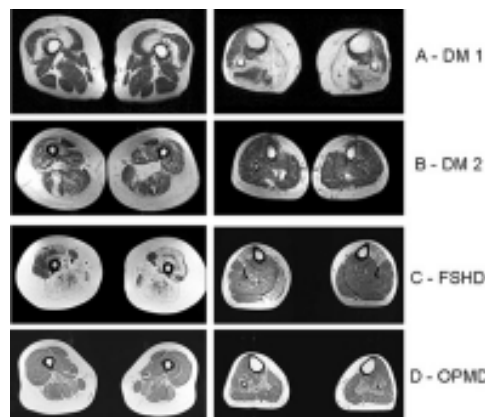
Muscle MRI of lower extremities muscular dystrophies.
